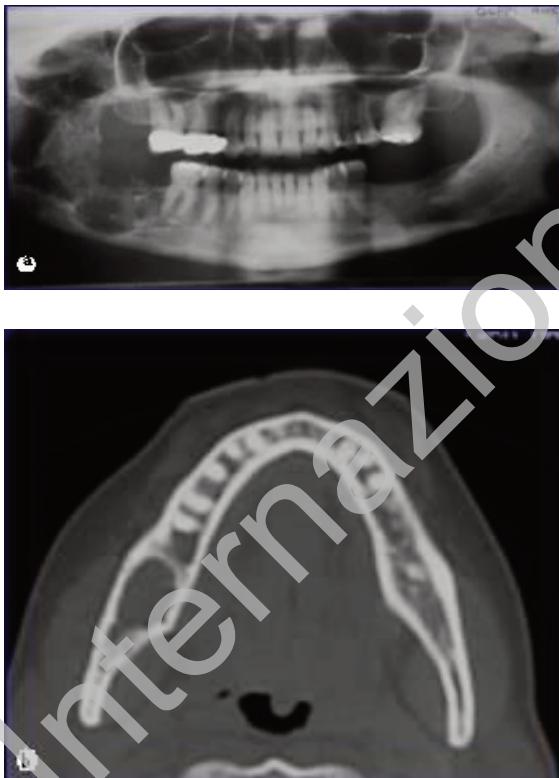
X-Ray Before surgery
